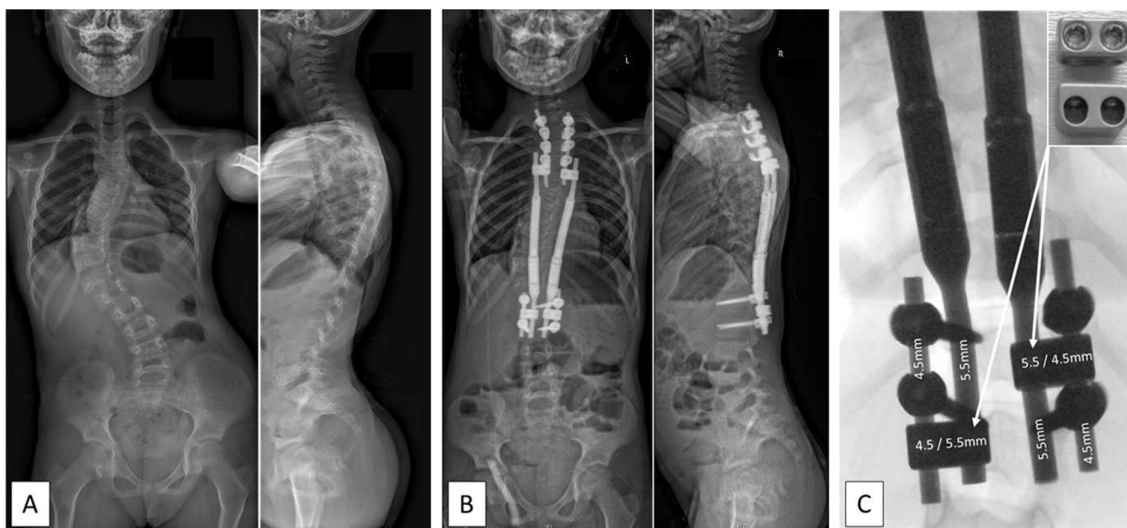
Radiographs of a six-year-old girl with an idiopathic early onset scoliosis before (a) and after (b) insertion of magnetically controlled growing rods (MCGR). A 4.5-mm system was used for the proximal and distal foundations and the foundations were linked to the 5.5-mm MCGRs by 4.5-/5.5-mm side-by-side rod connectors (c) enabling the use of two 90-mm actuator MCGRs.
